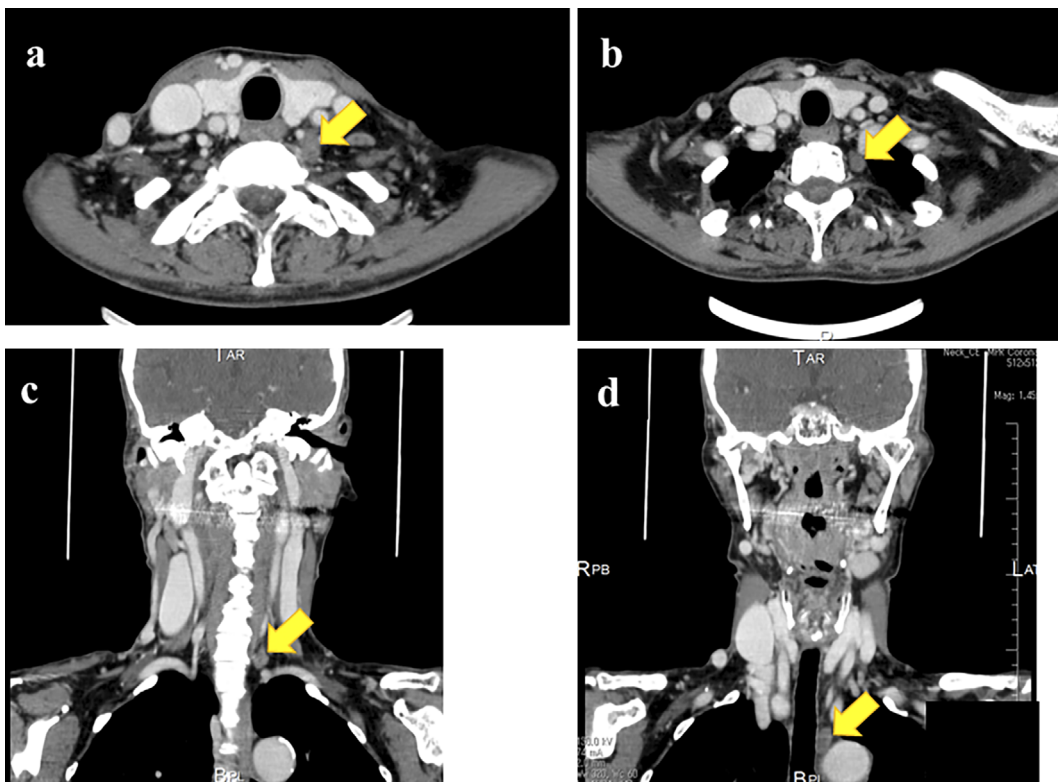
Cervical computed tomography. (a) Axial tomography image showing a tumor 15 mm in diameter on the dorsal aspect of the lower pole of the left thyroid gland (arrow). (b and c) Axial and coronal images showing a tumor 10 mm in diameter on the left side of the upper mediastinum (arrows). (d) Coronal tomography image showing a tumor 12 mm in diameter at the upper border of the aortic arch (arrow).
